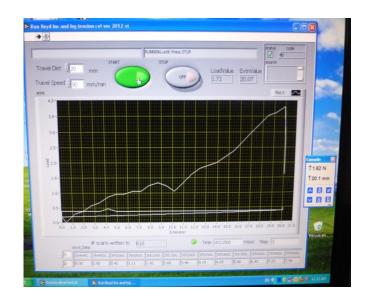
An example of the force deformation curve during ultrasound treatment of pre-rigor beef neck muscle.
